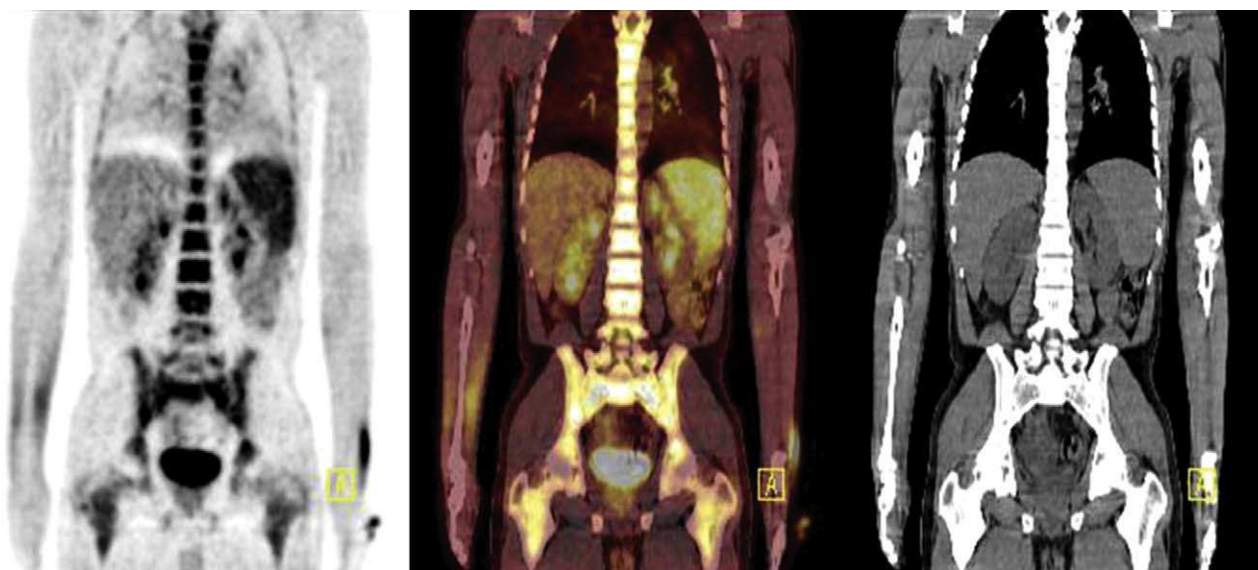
Coronal FDG PET/CT imaging demonstrating bone marrow infiltration.
